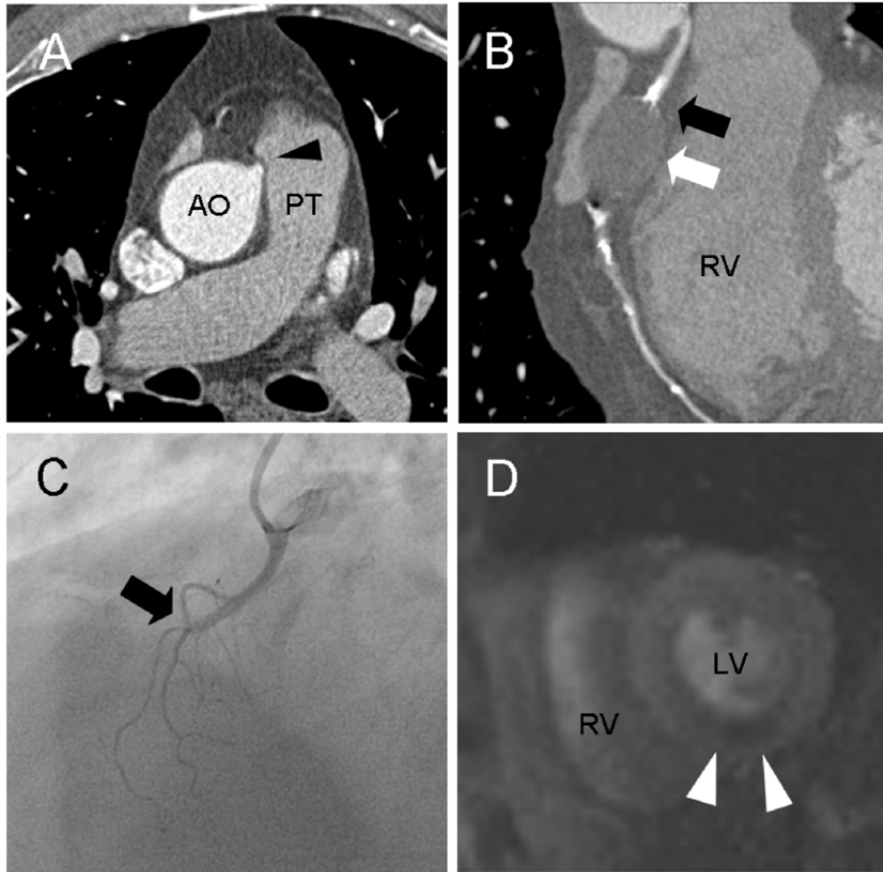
Panel A and B: Computed tomography coronary angiography images (A: axial orientation at the level of bifurcation of pulmonary trunk; B: Curved multiplanar reconstruction of anomalous right coronary artery); Panel C: Invasive coronary angiography image of right coronary artery; Panel D: First pass cardiovascular magnetic resonance image during adenosine stress in mid ventricular short axis orientation
